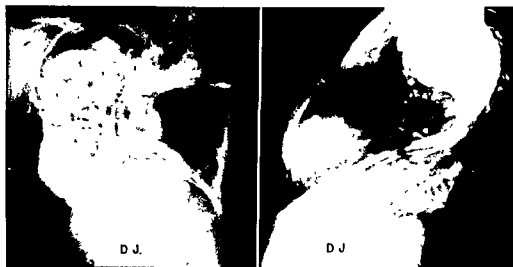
Patient D J, age 30 years, PA and lateral chest roentgenograms. Vital capacity, 675 ml, maximal breathing capacity, 31 L. per minute. Forced expiratory capacity, 1 sec., per cent of total vital capacity, 85 per cent. Resid. vol./total lung cap. ratio, 41 per cent. (Case referred by Chicago unit, Shriners Crippled Children's Hospital.)
